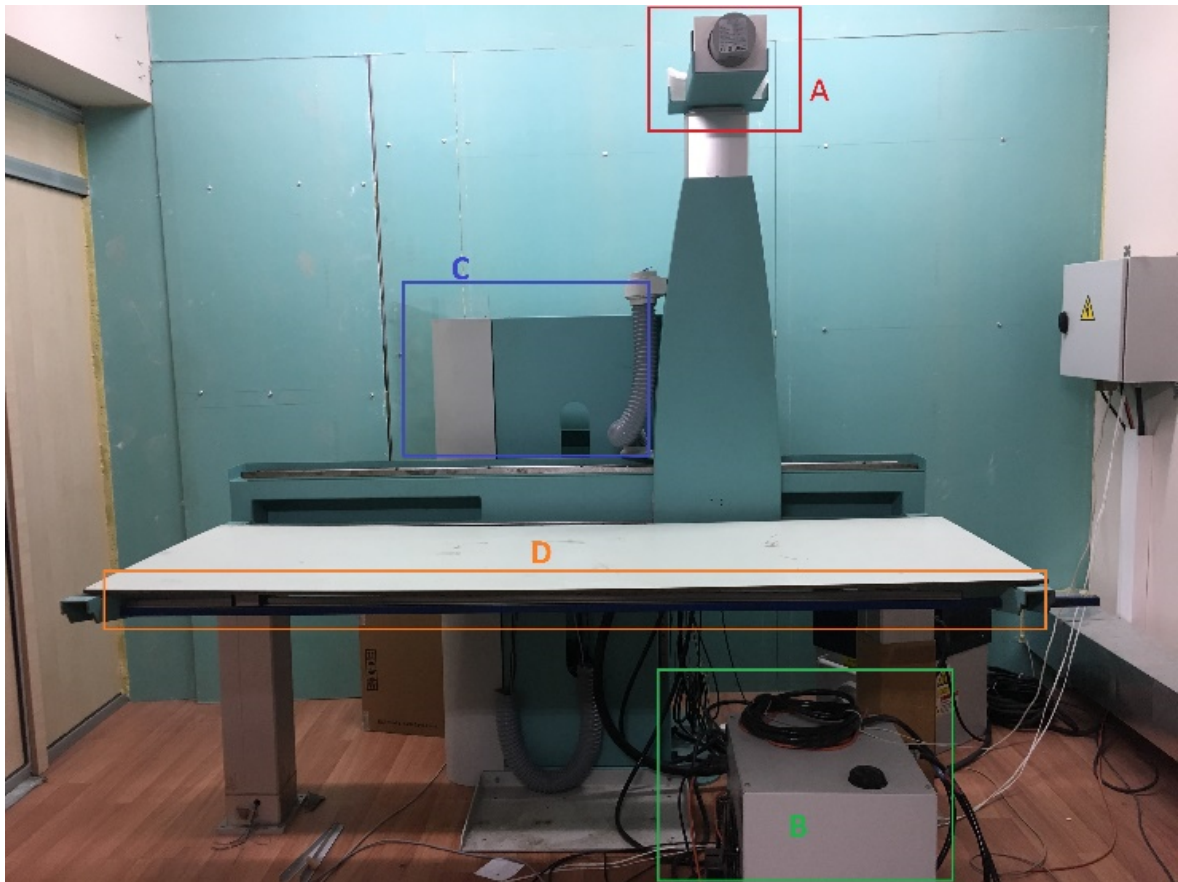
A TDI line scanner based full body X-ray scanner. SyncBox was employed to design and operate this configuration. A) X-ray tube B) High frequency generator system, C) Main body with servo motors, controllers and electrical system, D) Patient table combined with detector system. X-ray system includes all the main and some additional component that would be present in a standart X-ray system. For minimizing shifting between source, and detector, X-ray tube and line detector are moving along the same mechanical unit controlled by a single motor.
